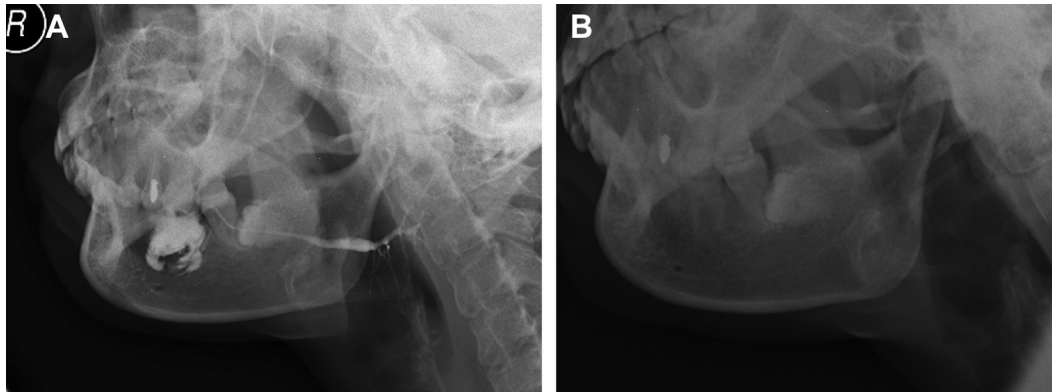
A 45-year-old woman with a 9-year history of stones in the right parotid gland. The stones were removed using method 5. She had no discomfort after the surgery. A, Follow-up sialography at 6 months showed a dilated main duct. B, Functional radiograph did not show persistent contrast.
